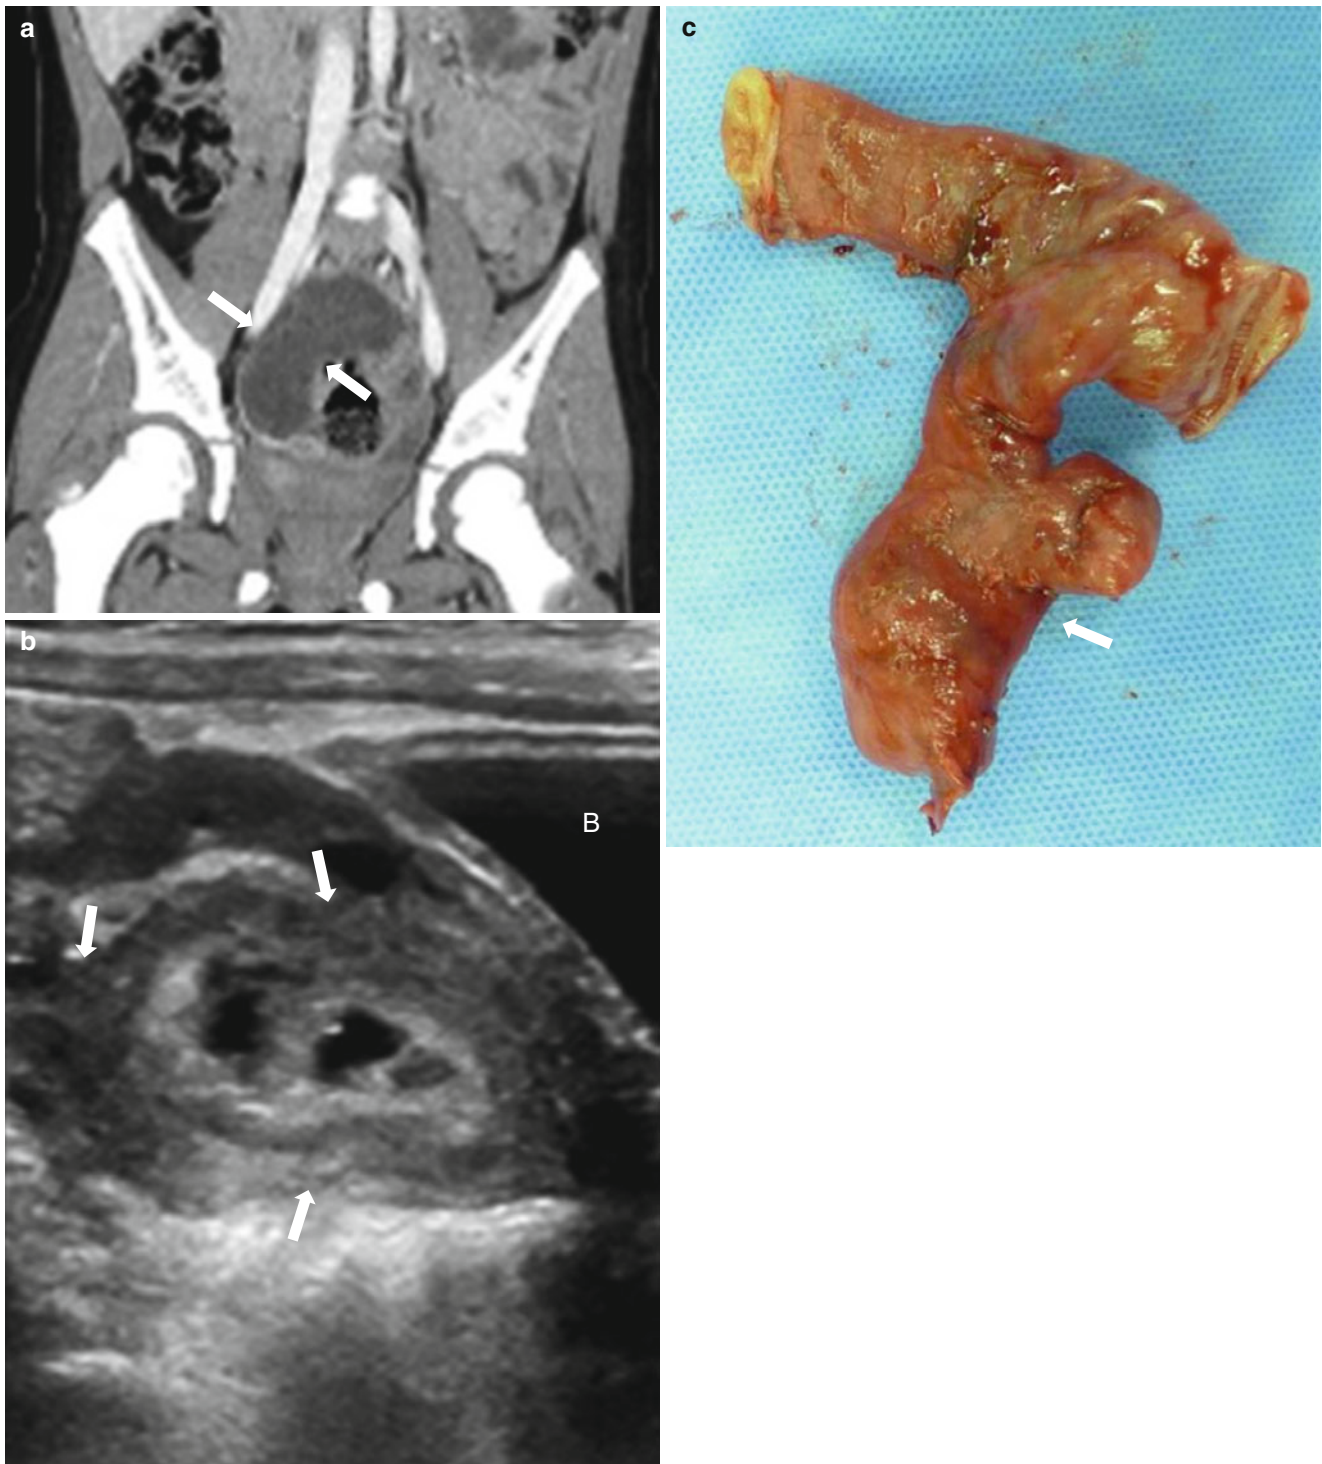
Complicated Meckel's diverticulum in a 4-year-old girl with acute abdominal pain. (a) Coronal contrast-enhanced CT image shows a blind-end fluid-filled tubular structure (arrows) in the pelvic cavity. The wall of this structure appears to enhance partially in the lower portion. (b) Longitudinal US image better depicts the inflamed wall (arrows) of the tubular lesion as well as the presence of focal
